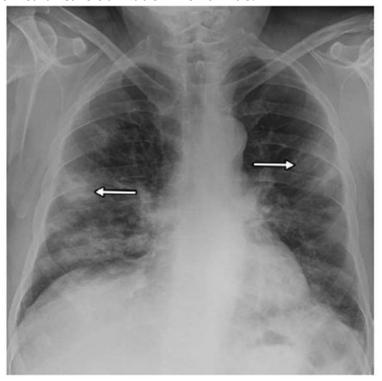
PA chest radiograph in a 58-year-old man with shortness of breath, cough, fever, and a history of COVID-19 exposure shows predominantly peripheral consolidative opacities in both lungs (arrows). These findings are highly suggestive of viral pneumonia due to COVID-19, especially in the context of the high prevalence of SARS-CoV-2 infection in the community.
